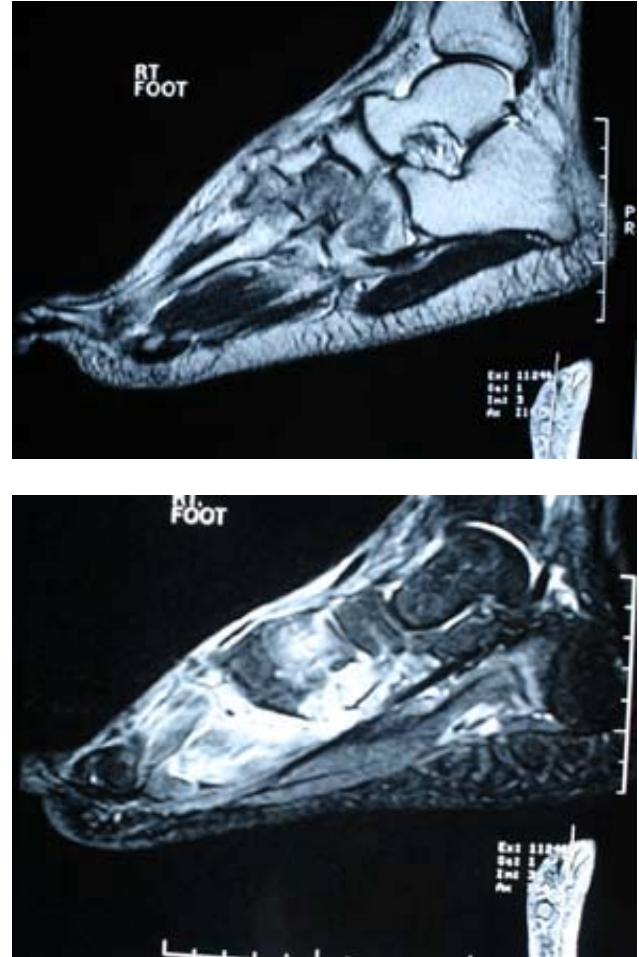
4 MRI shows extensive area of altered marrow signal noted in medial and lateral cuneiforms, as well as cuboid which show foci of hypo-intensity (on T1 weight images) along with interosseous edema. Talus, calcaneum, navicular, 1st,5th metatarsals, ankle joint, sinus tarsi are normal.
